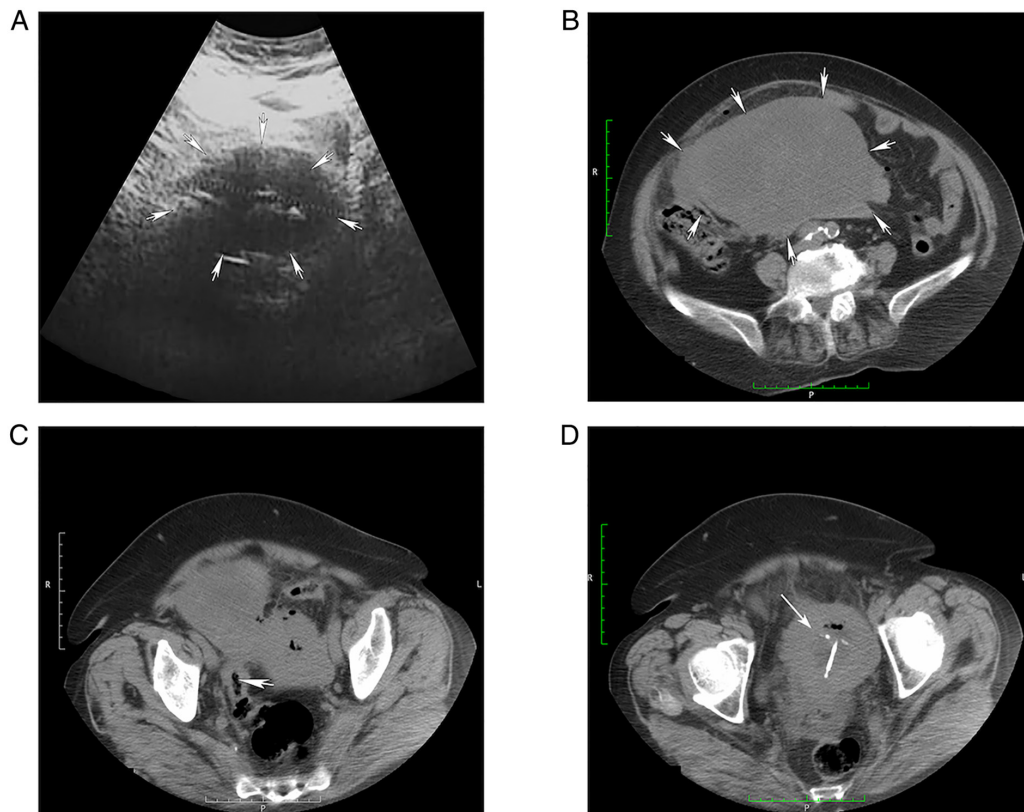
Preoperative imagistic findings. (A) Ultrasound showing a cystic mass with a complex echoic structure. (B) Axial CT image in the soft-tissue window showing a homogeneous pelvic mass (white arrows). (C) CT scan revealing a loop of sigmoid colon forming a common body with the ovarian tumor and multiple foci of gas, indicating a possible fistulous path between the two adjacent structures (white arrow). (D) CT evaluation revealing the intrauterine presence of an intrauterine device (white arrow). CT, computed tomography.
